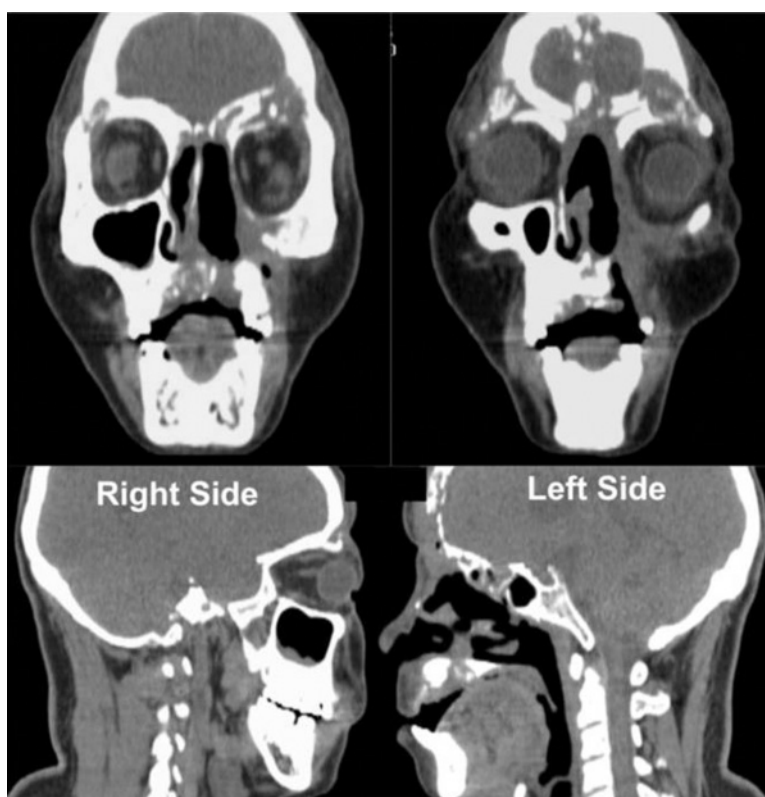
Two-dimensional computed tomography images of massive destruction of the bony structures of the left midface, extending into the frontal sinus region, in a patient with angiocentric B-cell lymphoma (midline lethal granuloma). (From Johnson *et al.*, 2007.)
